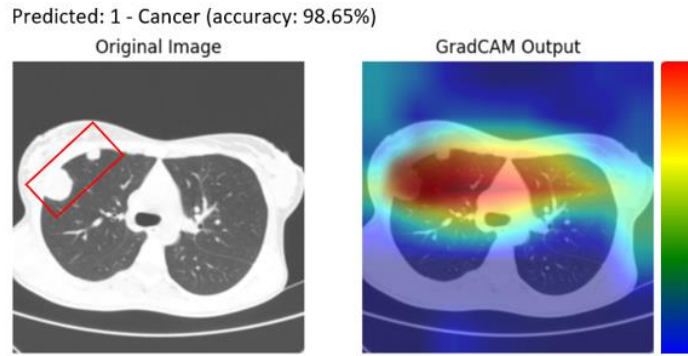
GradCAM result of CT image with a model of ResNet50
